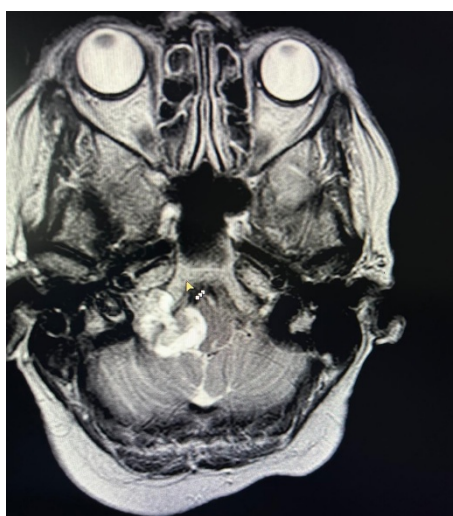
Axial contrast-enhanced MRI demonstrating a heterogeneously enhancing right jugular foramen mass with extension into the cerebellomedullary angle, causing mild compression of the medulla.
